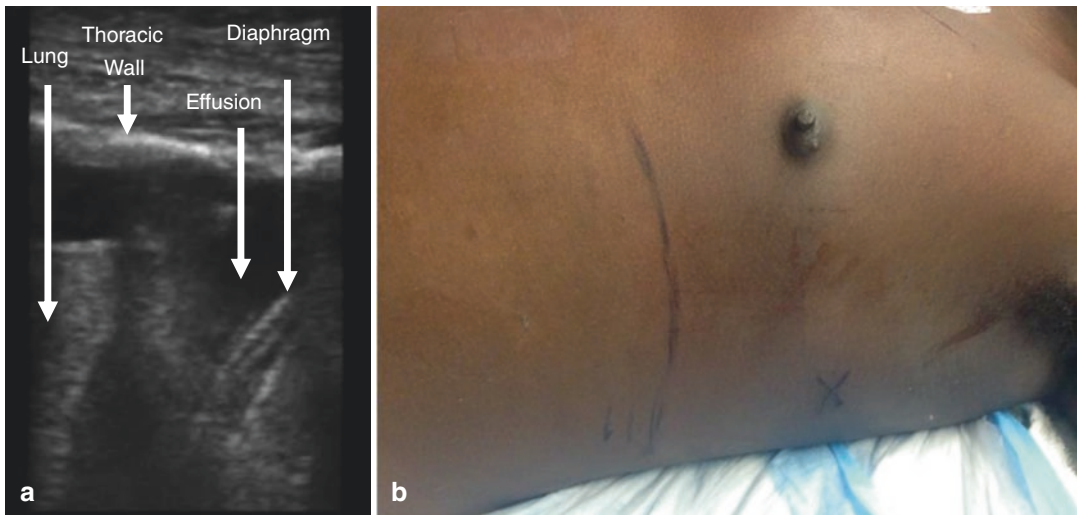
(a) Ultrasound image of pleural effusion with anatomic landmarks. (b) Marking on a patient of diaphragm location and optimal site for needle insertion
